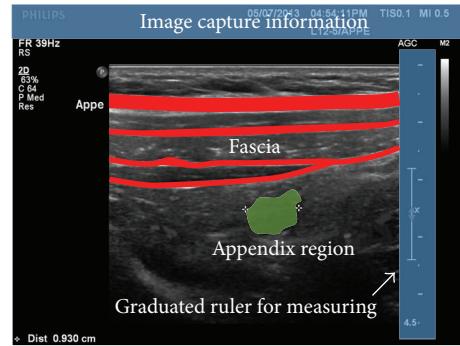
Typical input ultrasound image.
